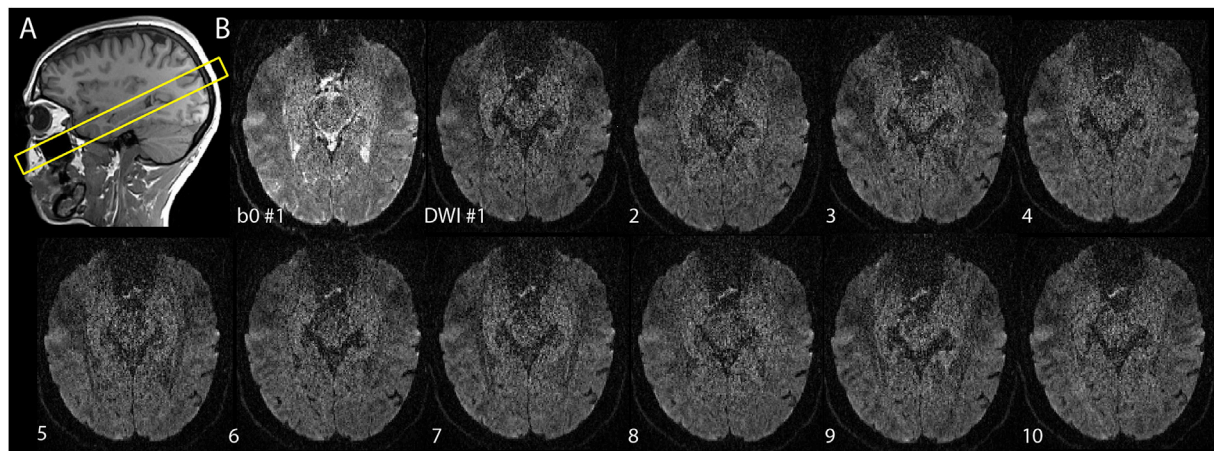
(A) A slab of twenty 1 mm axial-oblique slices aligned along the long axis of the hippocampus was acquired to reduce scan time and limit coverage to just the hippocampus, as prescribed on a sagittal slice of the 3D T1-weighted MPRAGE. (B) Examples of individual images, including 1 $b = 0$ s/mm² and 10 unique gradient directions at 500 s/mm². It is visually evident that despite signal boosting strategies, acquisition of 1 × 1 × 1 mm³ resolution produces very low signal-to-noise images (~3–5 in the hippocampus). Note that pre-scan normalize was used to minimize B1 sensitivity variations across the slice and improve visualization of the hippocampus.
